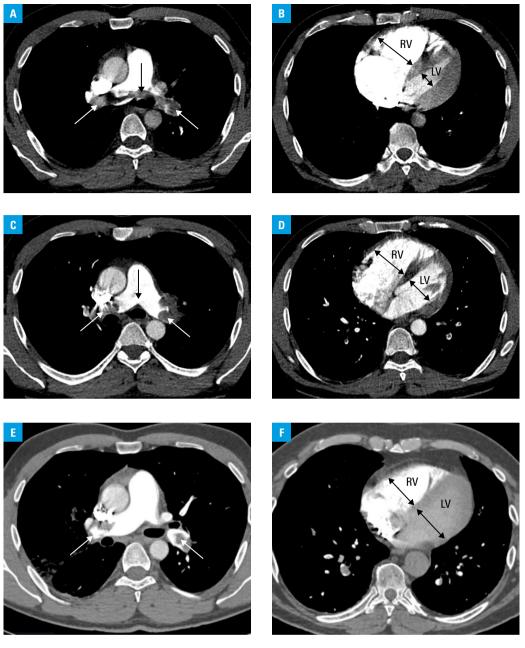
Computed tomography pulmonary angiography in a patient with high-risk acute pulmonary embolism showing saddle thrombus (black arrow) overriding the pulmonary trunk bifurcation with extensive clots in the right and left pulmonary arteries (PAs) (white arrow) (A) and dilatation of the right ventricle (RV) with the RV to left ventricle (LV) ratio of 2.2 (B), who was initially treated with systemic thrombolysis (ST) resulting in hemodynamic improvement, but persistence of dyspnea, occlusive clots in the proximal left and right PAs (white arrow) with sole resolution of the saddle thrombus (black arrow) (C) and RV dilatation (RV/LV ratio, 1.5) (D), and who eventually underwent percutaneous ultrasound-assisted low-dose local thrombolysis with the use of 2 catheters installed within clots, which led to withdrawal of symptoms, restoration of both PAs's patency (white arrow) (E) and reduction of the RV dilatation (RV/LV ratio, 0.9) (F).
